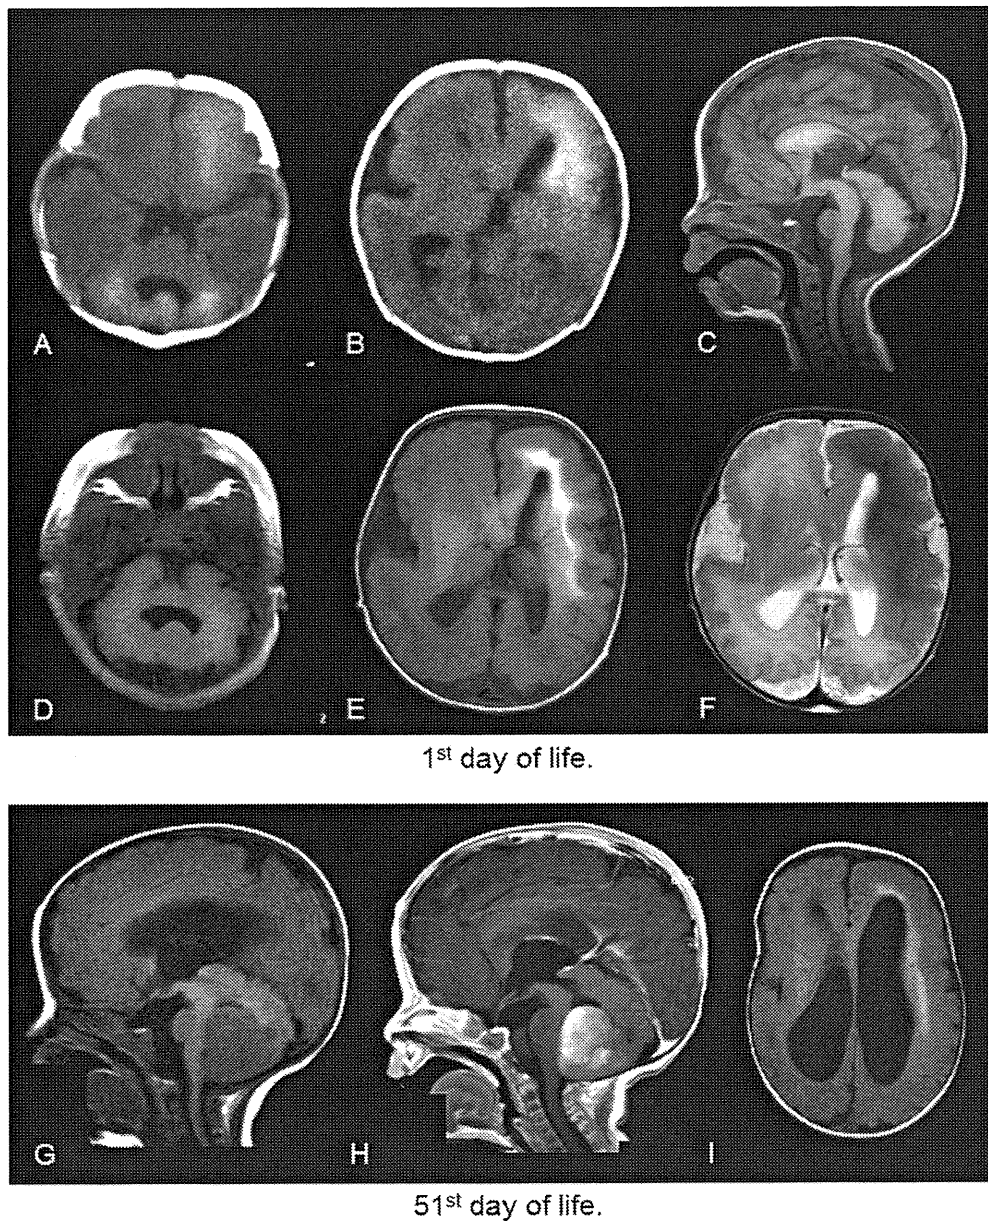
Neuroimaging findings. (A and B) CT on the first day of life. Poor gyral formation, aberrant fourth ventricle, and high densities in the left frontal area and cerebellar hemispheres were observed. (C–F) MRI on the first day of life. The corpus callosum was markedly hypertrophic in the anterior half (C). The mesencephalic tectum was enlarged and dysmorphic, and the pons was small (C). The cerebellar vermis was small and dysmorphic with insufficient folia formation (C). The cerebellar hemispheres were enlarged and wrapped around the brainstem (D). The cortical surface was smooth and gyral formation was poor (E and F). Caudate and lentiform nuclei were poorly differentiated from the surrounding structures (E and F). (G–I) MRI on the 51th day of life. A mass lesion was present at the posterior wall of the fourth ventricle (G). Tumor was enhanced by paramagnetic contrast agent (H). Ventriculomegaly with ballooning of ventricular walls was observed (I).
